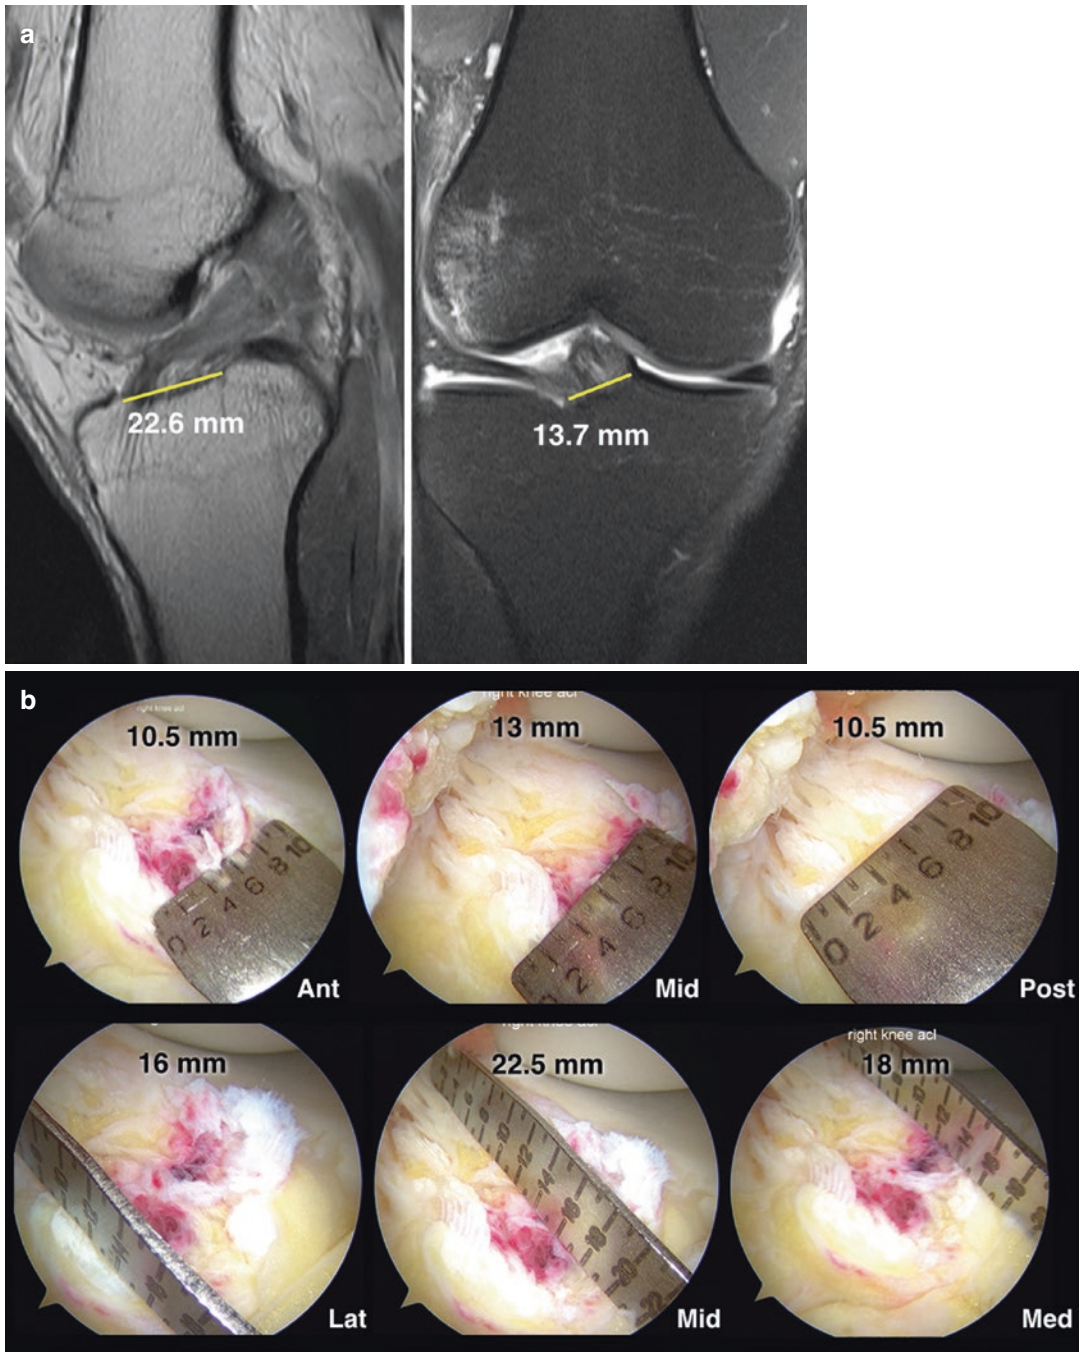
Clinical case. A 23-year-old male sustained a right knee injury during basketball. Physical exam revealed a 2B Lachman, +2 pivot shift, and 5-mm KT-1000 side-to-side difference. (a) The sagittal and coronal MRI showed a complete ACL tear. Preoperative measurements showed a large insertion site (tibial sagittal length >18 mm). DB ACL reconstruction was indicated. (b) Intraoperative measurements, following the anatomic
